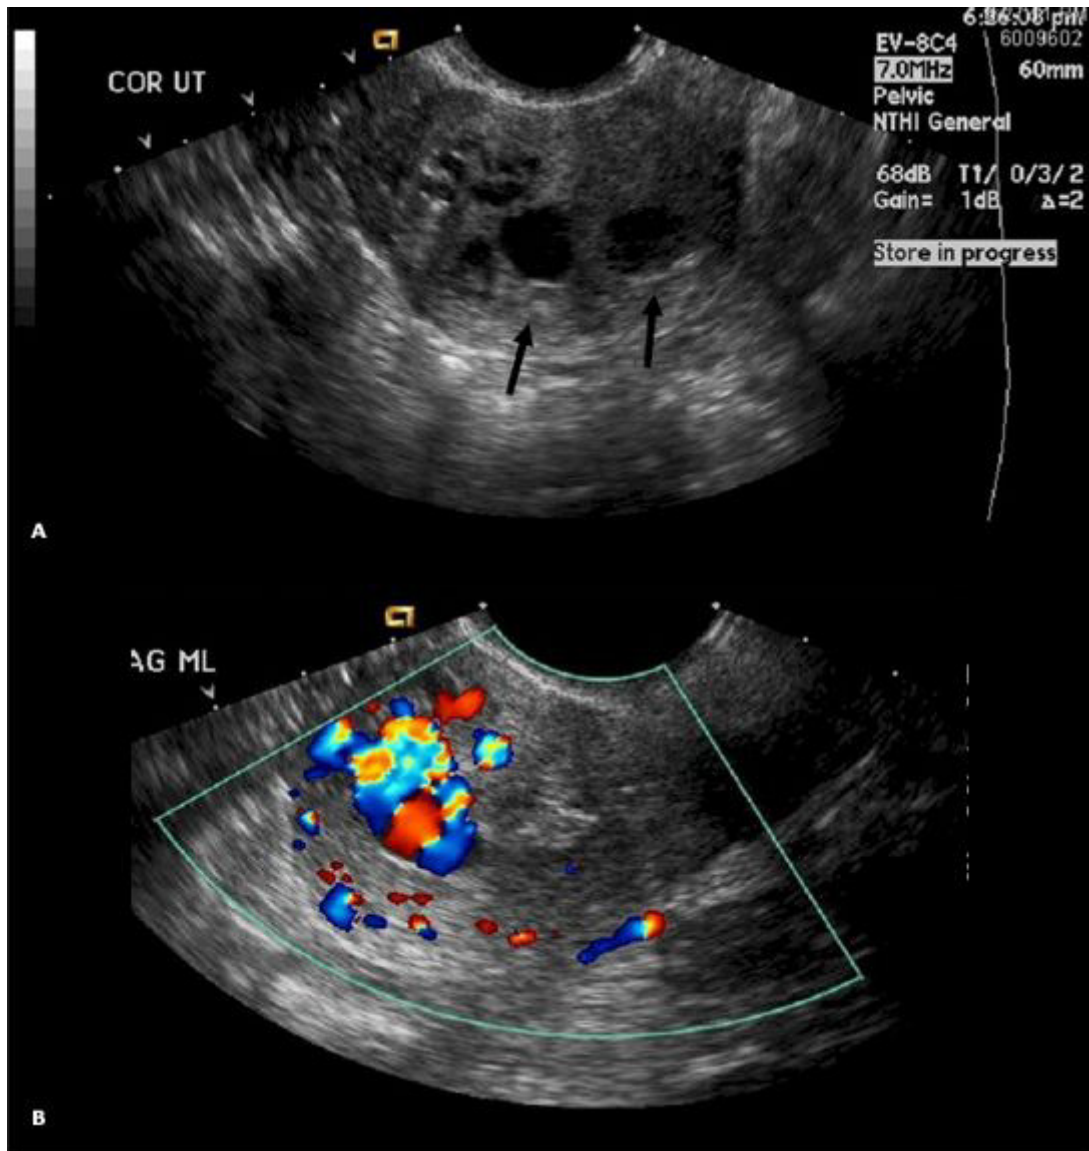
Ultrasound of the pelvis demonstrates hypoechoic regions (arrows). (B) Duplex color Doppler ultrasound shows a hypervascular lesion within the fundus that measures 2.6x2.3x1.3 cms, consistent with arteriovenous fistula or malformation. She was s/p TAB at 14 weeks, 5 months.
